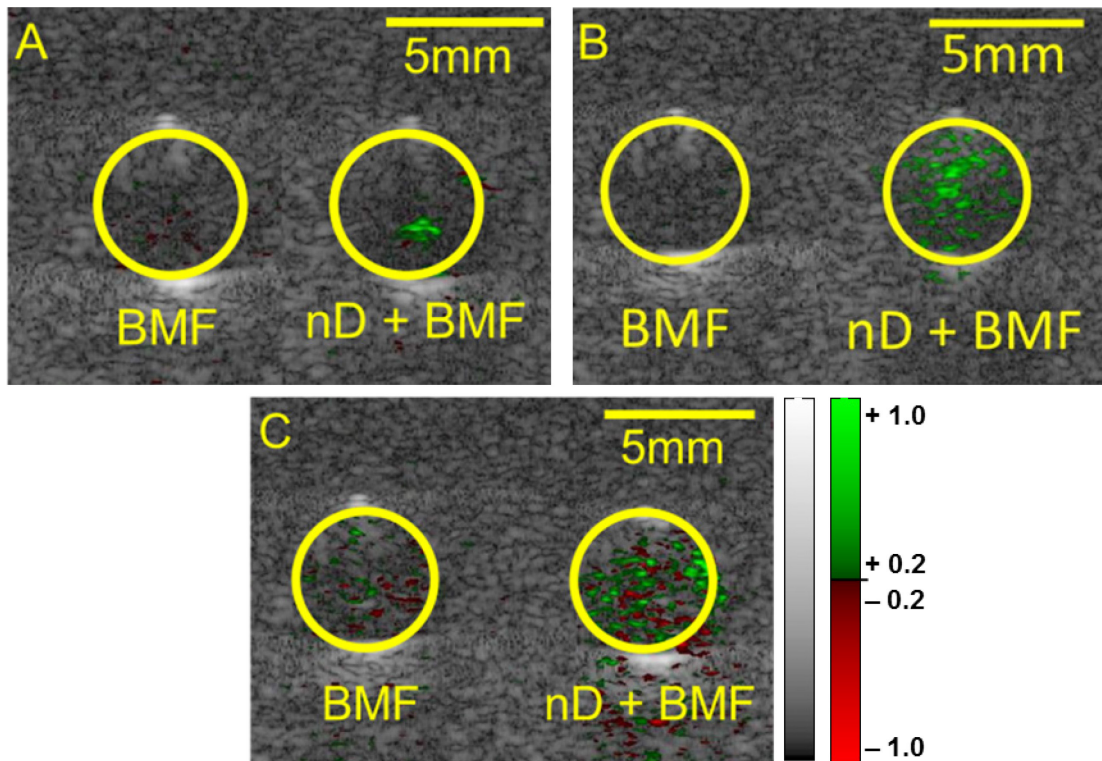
Flash-difference images with a single angle image sequence of nanodroplets. Two tubes were placed 2 cm deep in tissue mimicking gelatin. Blood mimicking fluid (BMF) with or without 2% nanodroplets (nD) flowed through the tubes (shown as yellow circles). Experimental parameters for each case are as follows: A) 100 cycles at 1.0 MI with 1.0 mL/min flow rate. B) 100 cycle at 1.7 MI with 1.0 mL/min flow rate. C) 100 cycles and 1.7 MI with 6.0 mL/min flow rate. The gray and red-green colormap represents ultrasound signal before the HIFU pulse and the percent change in ultrasound signal after the HIFU burst, respectively [35].
